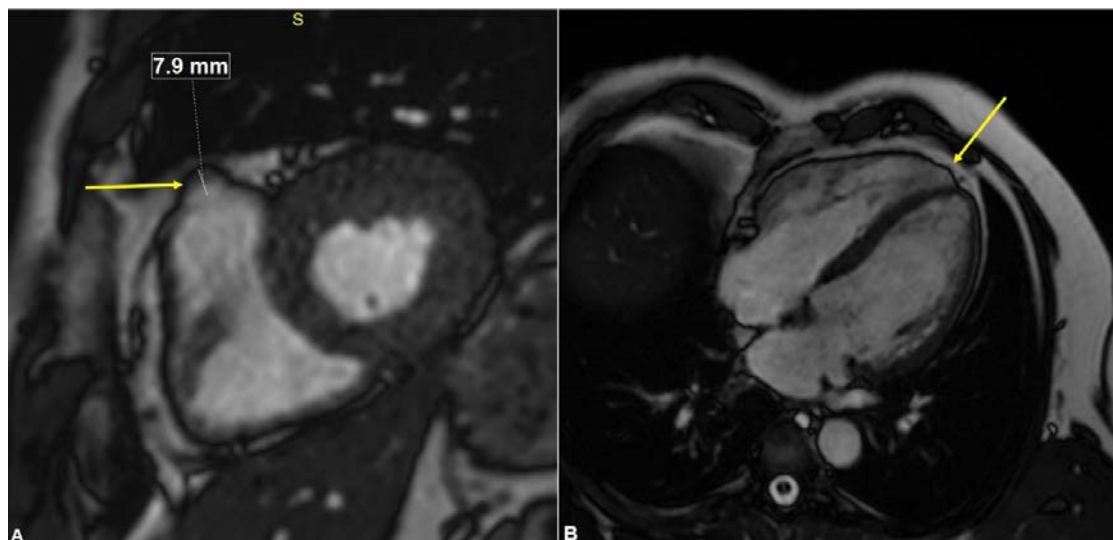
Heart magnetic resonance imaging shows A) aneurysmatic dilatation of the right ventricle in the basal part with 7.9 mm (yellow arrow) and B) apex of the right ventricle (yellow arrow).
